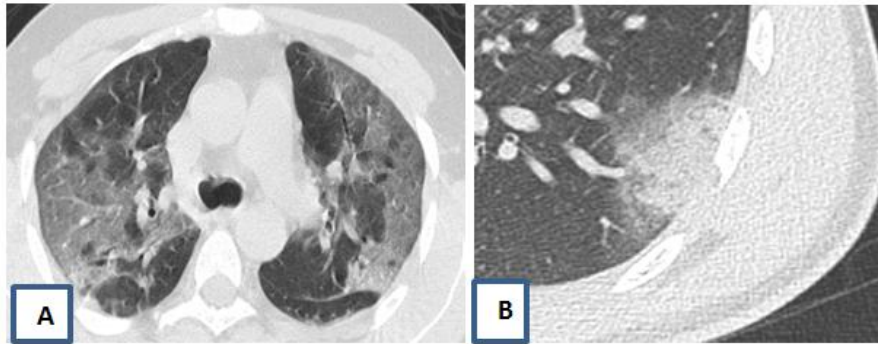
Chest CT with axial plane showing other signs: A- Ground-glass opacity with superimposed interlobular septal thickening and intralobular septal thickening « crazy paving » B- Nodule with ground-glass halo in the left lower lobe « halo sing »
